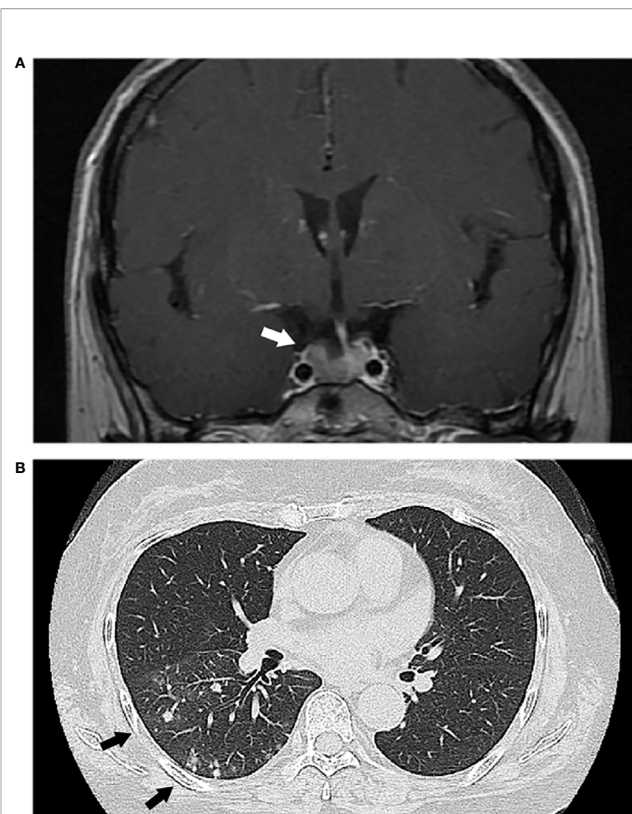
(A) Magnetic resonance imaging showed a pituitary adenoma (white arrow). (B) Chest computed tomography revealed multiple lung nodules (black arrows).
